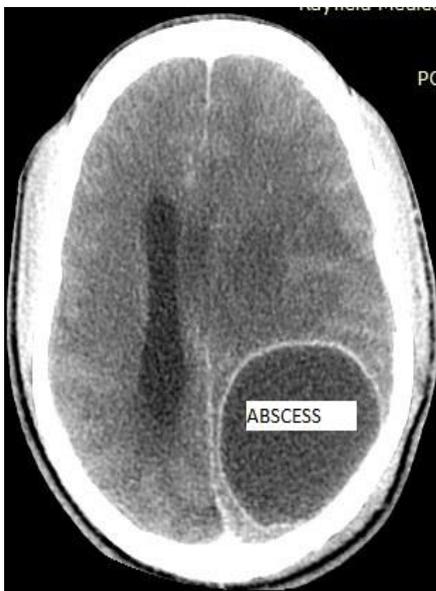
Contrast enhanced CT scan showing a huge left parieto-occipital intracerebral abscess with effacement of ipsilateral ventricle.
